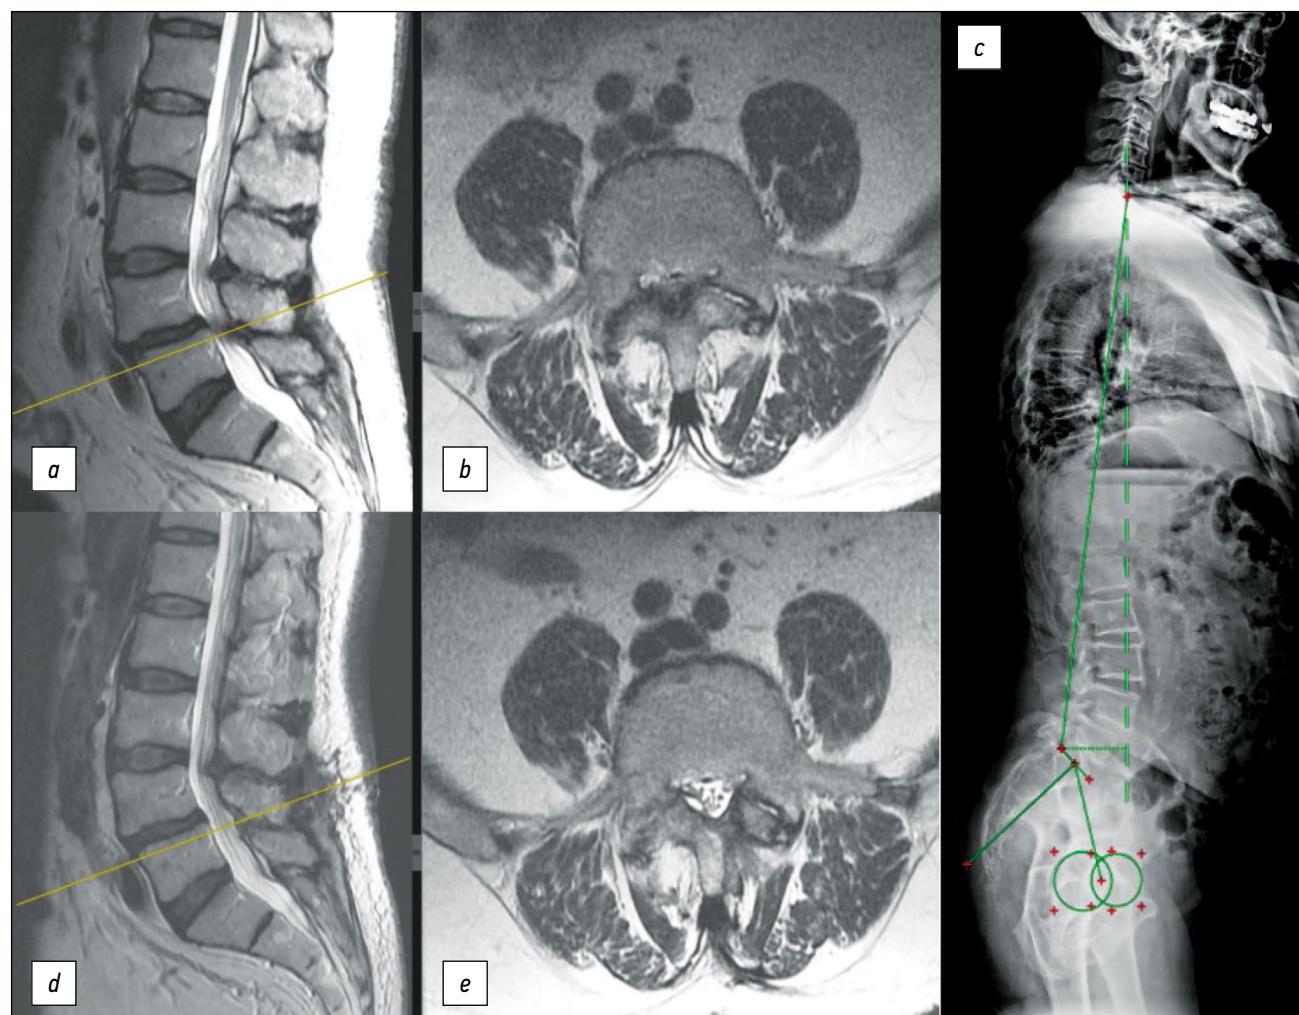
Patient B., 83 years old. VAS in back — 5 points; VAS in leg — 8 points. ODI=47.5%. DN-4 — 2 points. MRI of the lumbar spine — degenerative stenosis L4-L5 Schizas grade D, degenerative spondylolisthesis L4 grade I. (Fig. 1, a, b). Postural radiography of the spine — Barrey Index = 1.76 (Fig. 1, c). Surgical treatment — microsurgical "over-the-top" decompression at L4-L5. Lumbar spine MRI after 1 year — recalibration of the spinal canal to Schizas grade A4 (Fig. 1, d, e). ODI — 4.0%, VAS in leg — 0 points, VAS in back — 3 points. Regression according to ODI by 43.50%, recalibration of the spinal canal confirmed, satisfaction with surgical treatment on the Likert scale: 5 — "Much better than before the surgery". Treatment success achieved.
